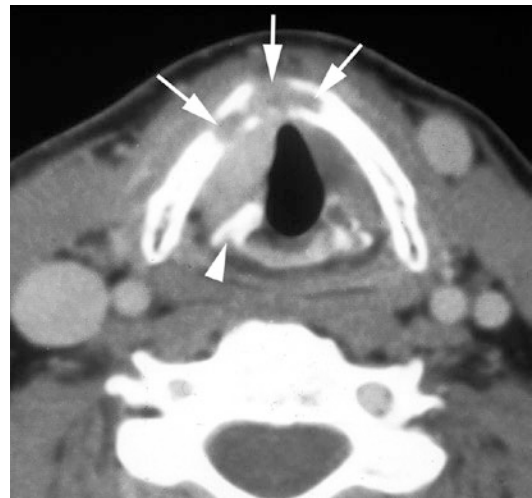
Axial contrast-enhanced CT image in a patient with a clinically T3 glottic cancer on the right side. Thickening and increased enhancement of the right true vocal cord. Sclerosis of the right arytenoid cartilage (arrowhead) and lysis of the anterior part of the thyroid cartilage, containing enhancing tissue (arrows). The patient was treated by definitive radiotherapy; long-term local tumor control was achieved
